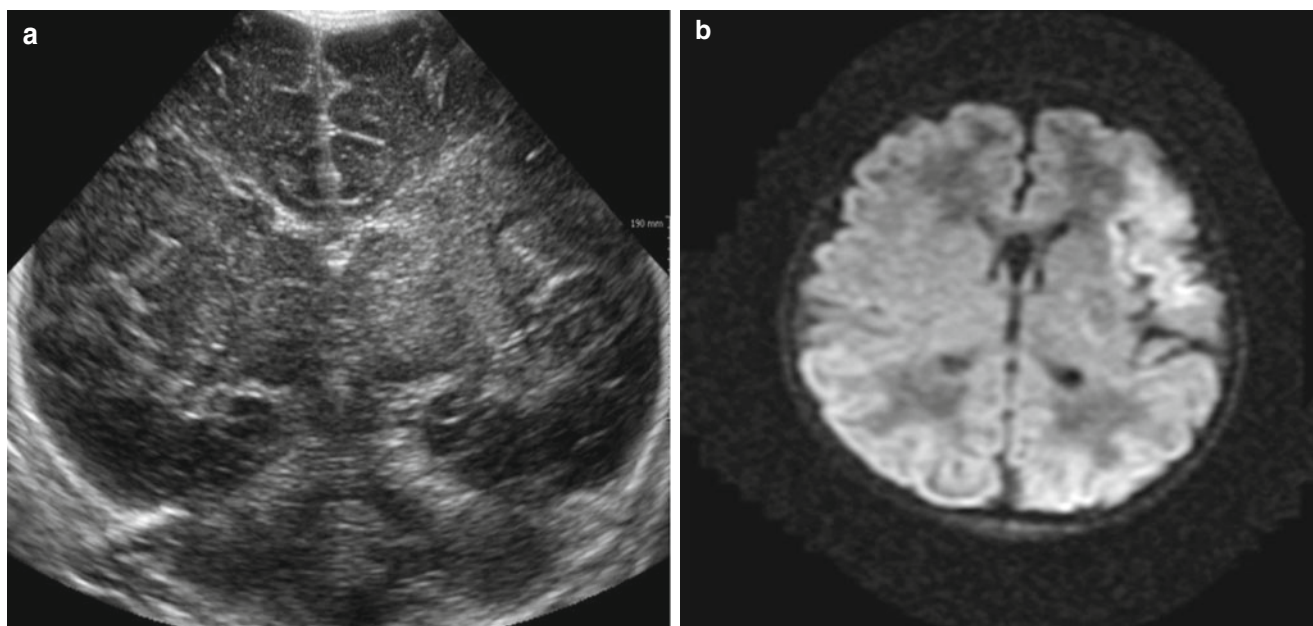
Left middle cerebral infarction in a 2-day-old male infant at 39+1 weeks gestational age. (a) Coronal scan shows asymmetrical, increased echogenicities of left MCA territory. (b) On diffusion-weighted MR image, left MCA infarction can be confirmed
